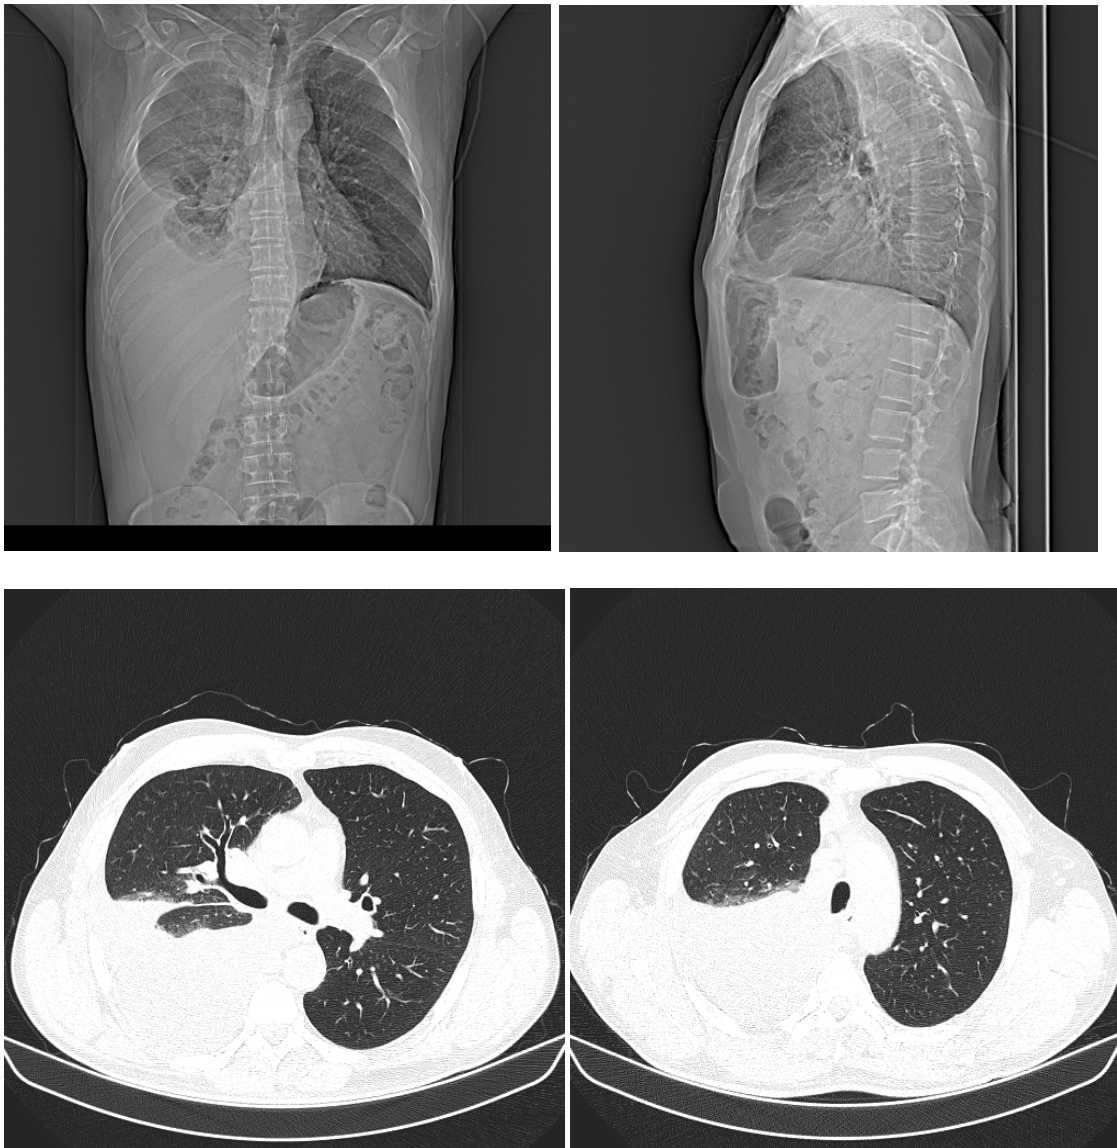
Computed tomography of the chest
